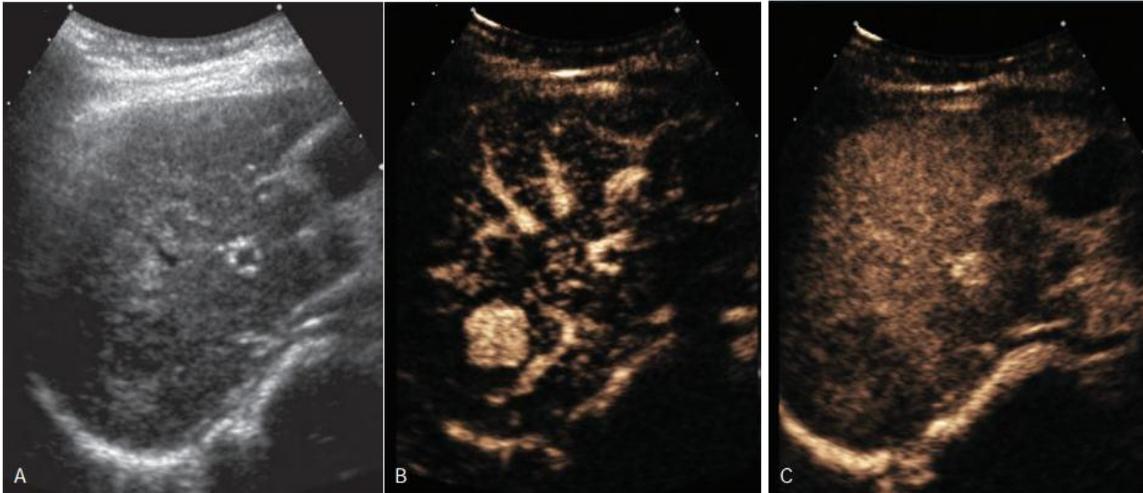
Classic hepatocellular carcinoma (HCC) detected on surveillance ultrasound.
